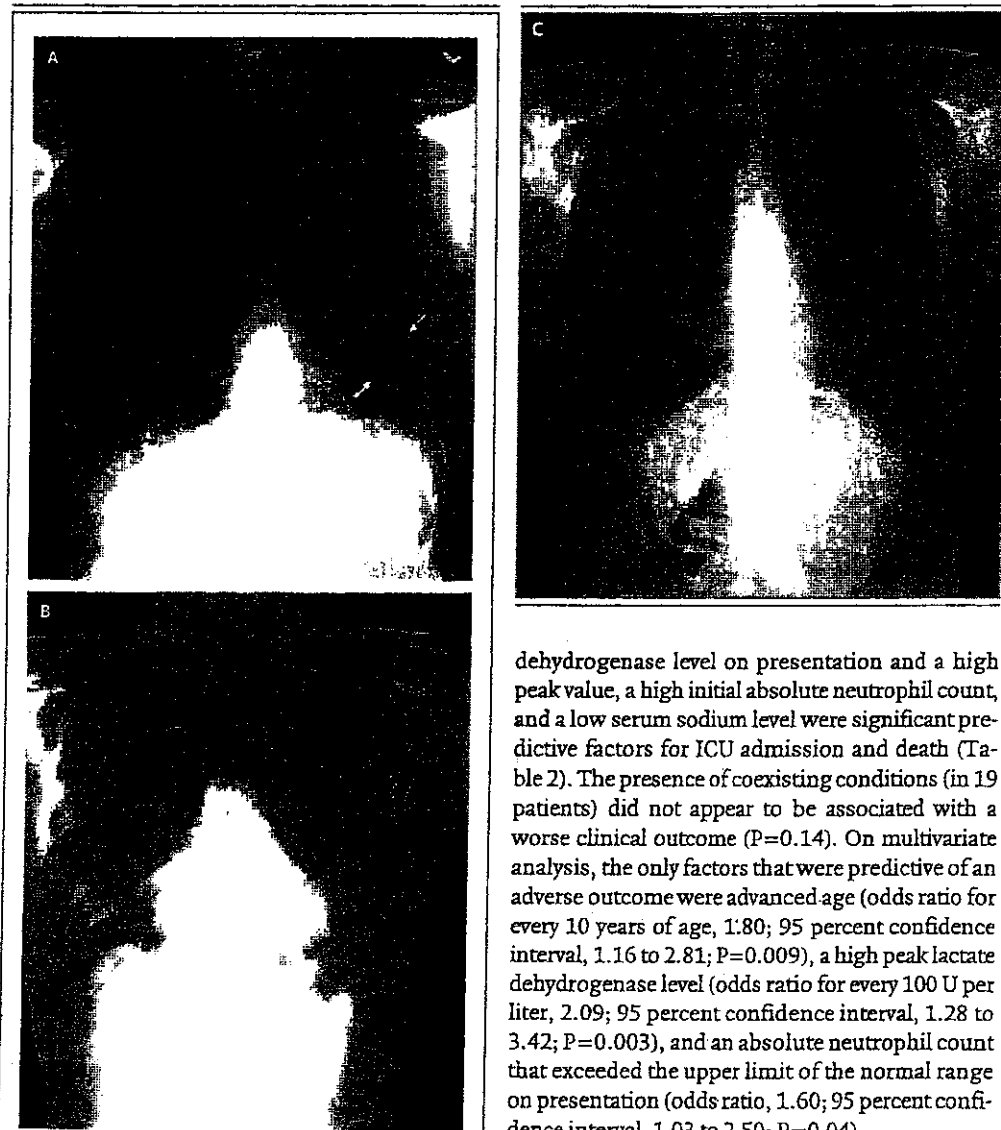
Frontal Chest Radiographs in a 46-Year-Old Man. Panel A shows an obvious area of air-space shadowing (arrows) on the left side. A follow-up chest radiograph showed progression of the disease, with multiple bilateral areas of involvement (Panel B). A subsequent chest radiograph shows improvement of bilateral lung opacities after therapy (Panel C).
